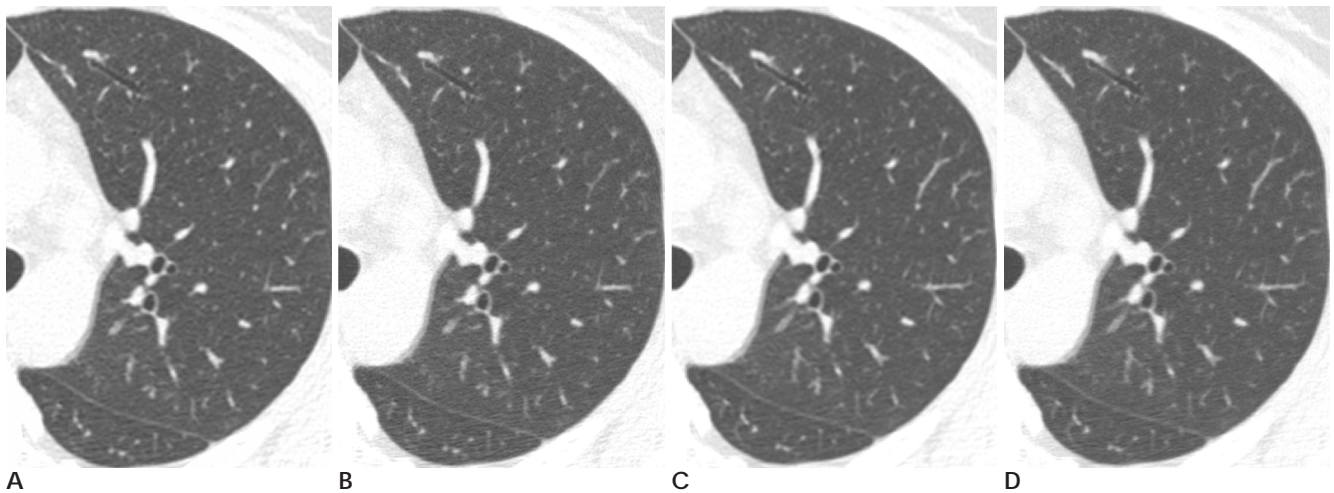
Comparison of axial CT image with different matrix size and slice thickness.
